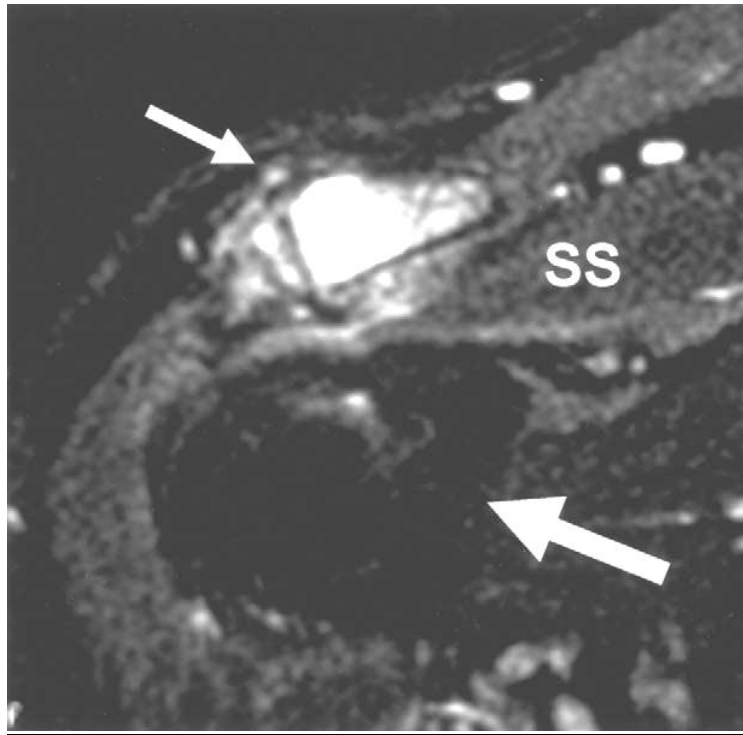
MRI scan of right AC joint in a symptomatic patient demonstrating joint space narrowing, osteophytes, and bone edema in the lateral clavicle and medial acromion. SS, supraspinatus. (Shubin Stein et al 2006)
